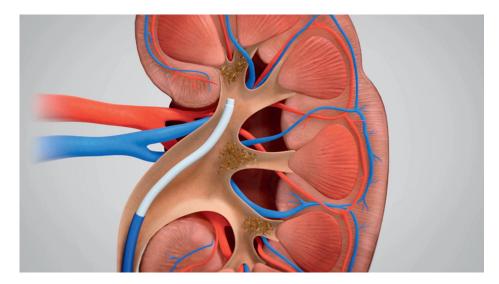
The CVAC device is deployed through a 12F/14F ureteral access sheath and guided through the renal collecting system fluoroscopically or by ultrasound. © 2023 Calyxo, Inc. Reprinted with permission.
